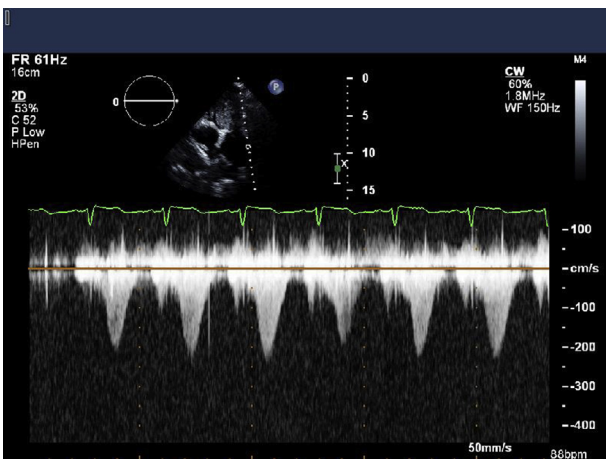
Doppler imaging across the pulmonic valve showing an increased gradient along the path of the Doppler beam, most likely due to tumor blood flow obstruction.
